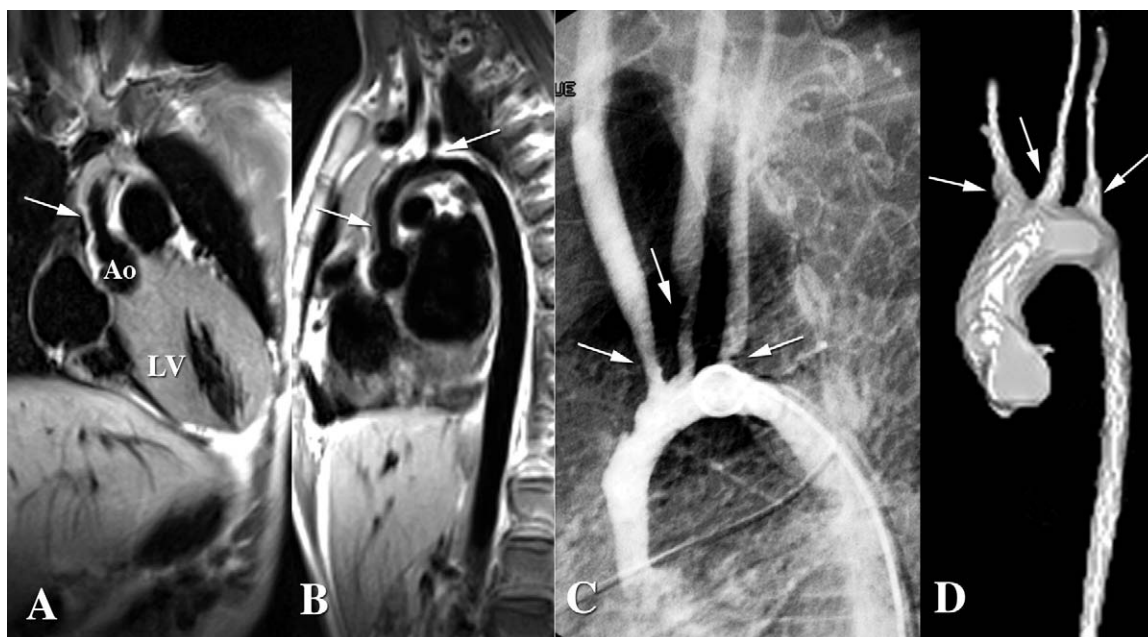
Preoperative magnetic resonance imaging (patient 7) showing severe obstructive hypertrophic cardiomyopathy of the left ventricle (A) and thickening of the aortic wall (B). C, Preoperative angiography showing narrowing of the ascending aorta and the aortic arch and stenosis of all cervical branches. D, Postoperative magnetic resonance imaging 2 years after homograft replacement of the ascending aorta, aortic arch, and proximal segments of the supraortic trunks, with no evidence of homograft calcifications or degeneration.
